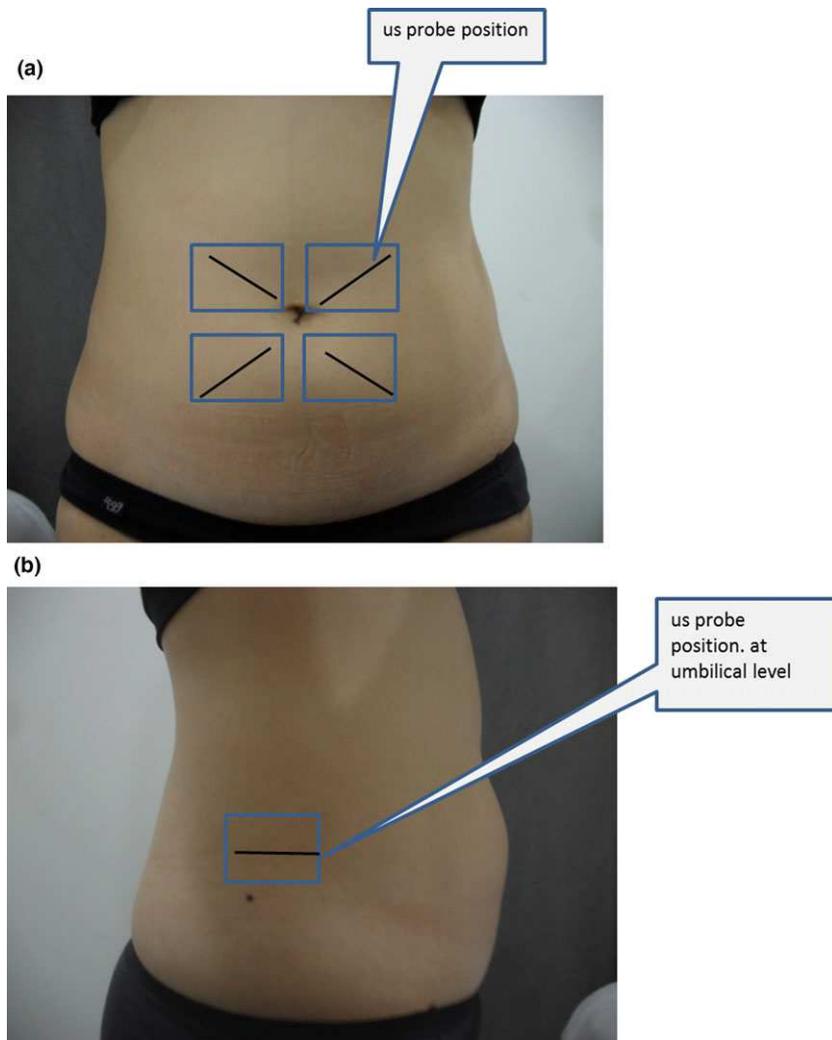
Placement site for abdomen and flank ultrasound measurements.
